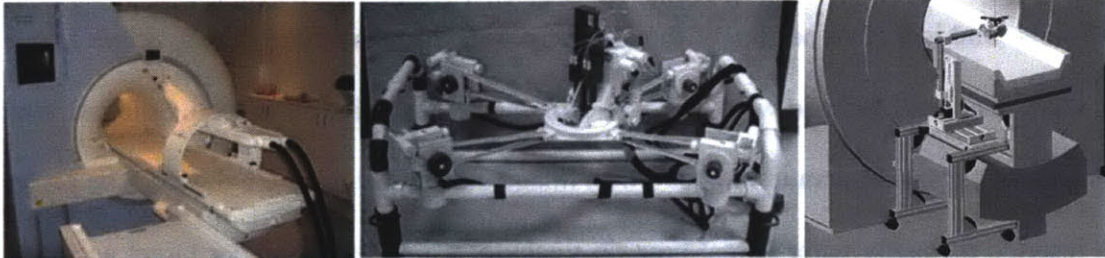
Large MRI compatible devices for positioning probes. Left: InnoMotion pneumatic robot from Innomedic [9]. Middle: The light puncture robot (LPR) is attached to a frame that rests over the patient [10]. Right: MR-guided microwave thermoablation device [11]. These devices are not designed to place multiple probes.
